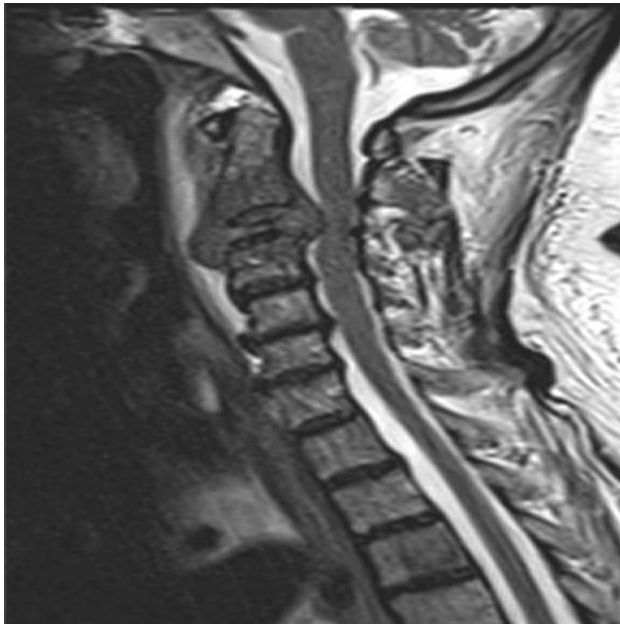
Sagittal T2-weighted magnetic resonance imaging demonstrating a C3 lesion causing pathologic collapse and ventral cord compression
